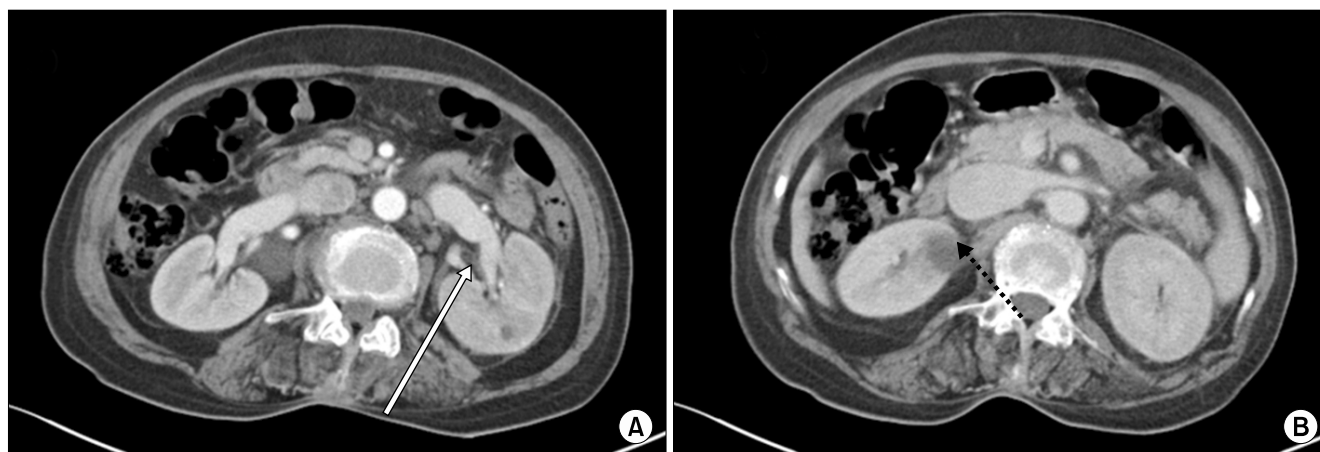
Computed tomography scans of the second patient. (A) Contrast-enhanced (B) delayed phase show diffuse left renal swelling and left perinephric fat infiltration. Diffuse wall thickening of the left ureter (line arrow). Simple renal cyst (dotted line arrow).
